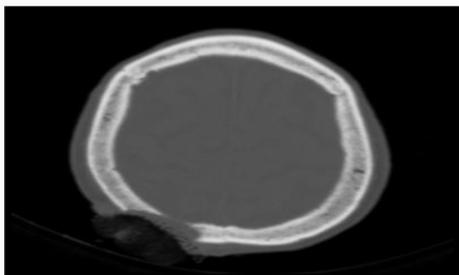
CT showing extent of skull invasion.
